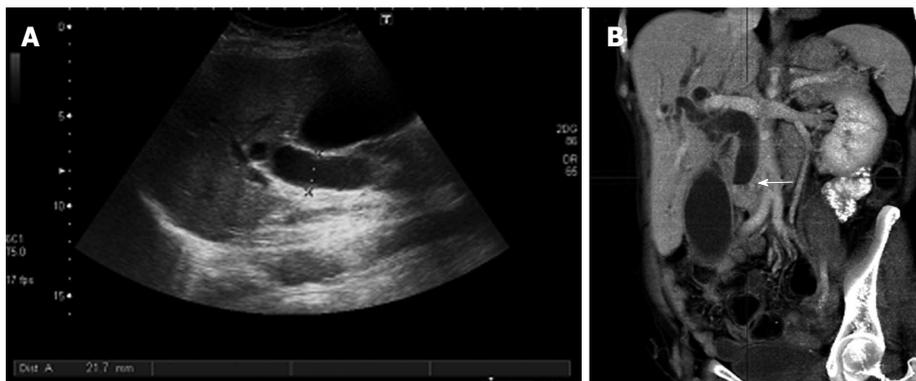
Indirect signs of pancreatic neoplasms. Transverse ultrasound image (A) shows a markedly dilated common bile duct, also seen on the coronal reformation image of multidetector computed tomography (B) where the dilated duct terminates abruptly at the level of the pancreatic head (arrow).
